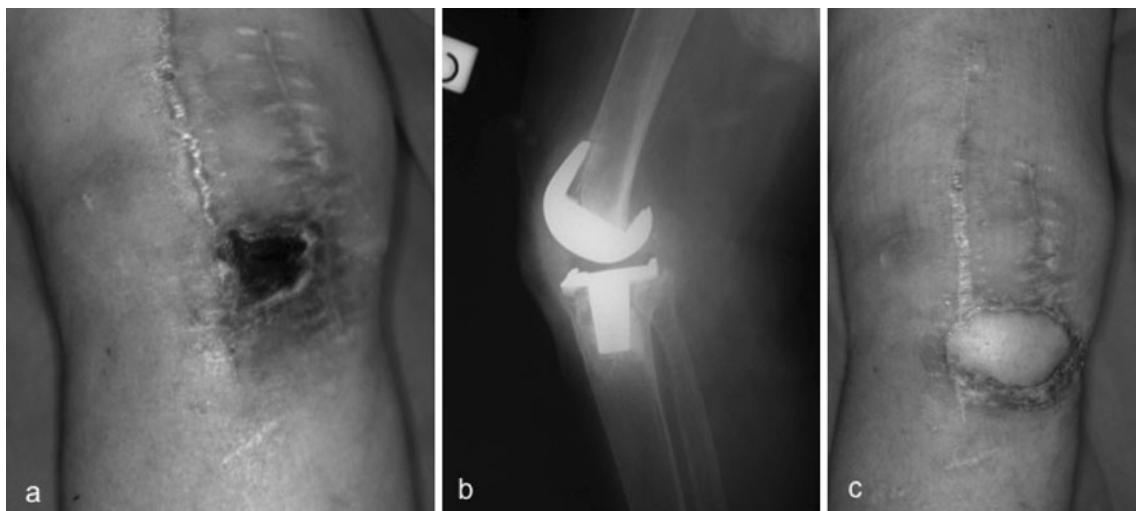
a Cutaneous necrosis after surgical incision near previous scar. b Radiographic view of the implant. c Clinical aspect at the follow-up
